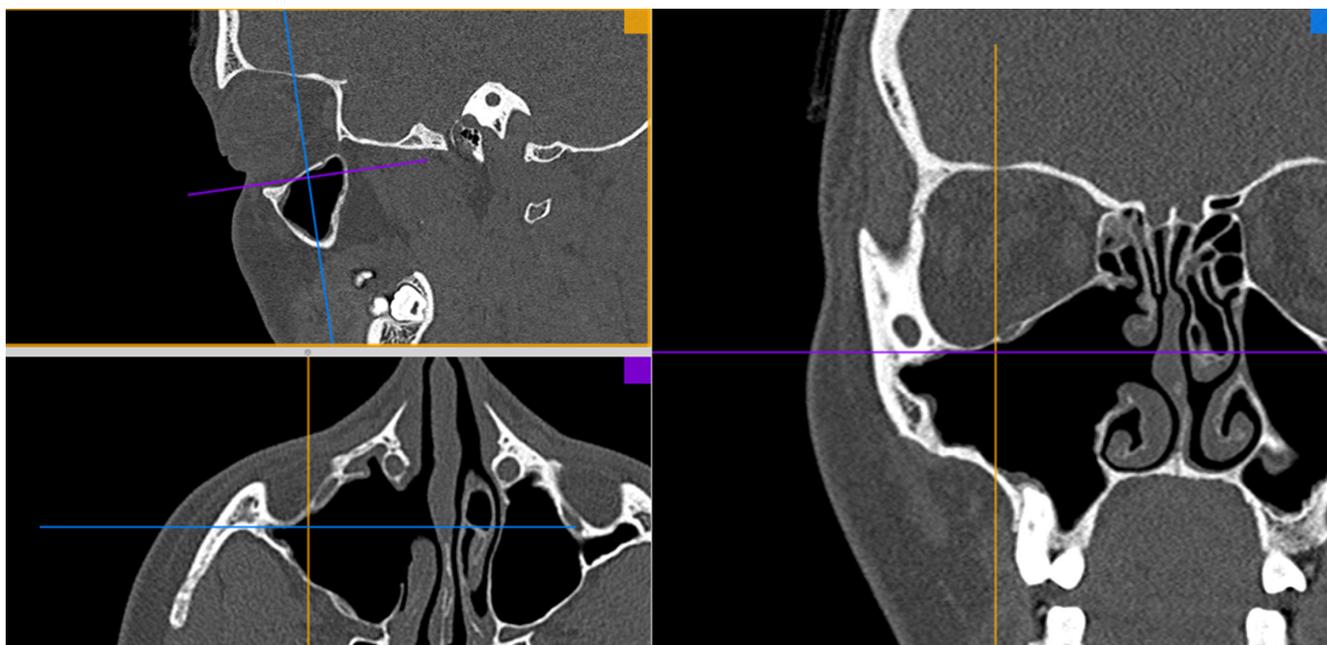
Computed tomography imaging. Condition after extraction of ectopic tooth, without signs of sinusitis.
